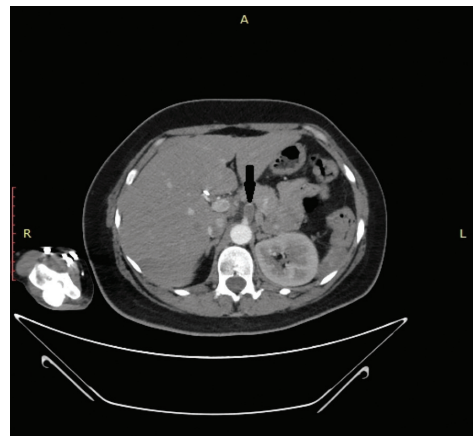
Contrast-enhanced CT of the abdomen demonstrates total occlusion of the Celiac artery (arrow).
